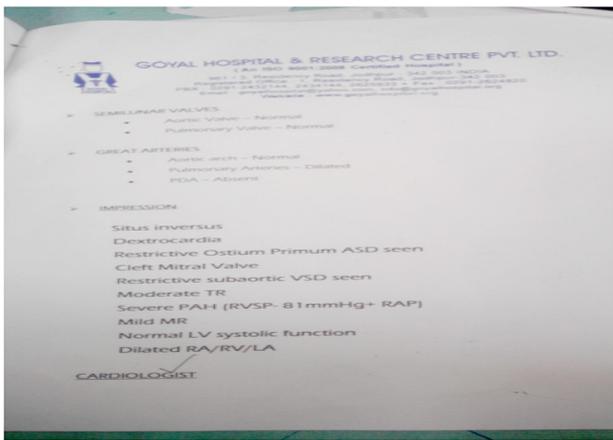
Echocardiography report.
